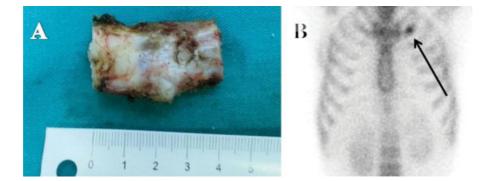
(A) In a 22-year-old man after 12 months of his admission, the swelling on the left first costochondral junction had doubled and excisional biopsy was done. The pathological examination was chondritis. (B) The preoperative Tc-99 M bone scintigraphy of the same patient shows an increased uptake of radioactivity on the left first costochondral junction (arrow).
